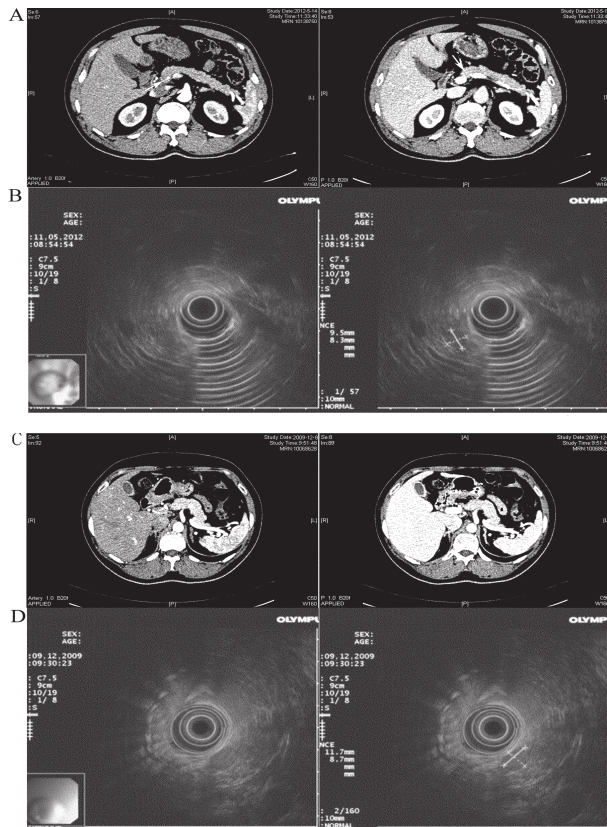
The imaging studies between CT scan and EUS (A and B) CT scan and EUS can both detect the tumor in the pancreas. (C and D) the EUS detect the tumor in the pancreas, but CT scan not
